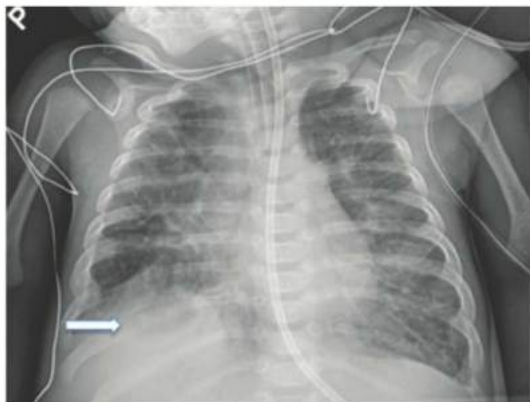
• Chest x-ray demonstrating a right CDH. The arrow denotes the elevated liver at the site of the hernia defect.
